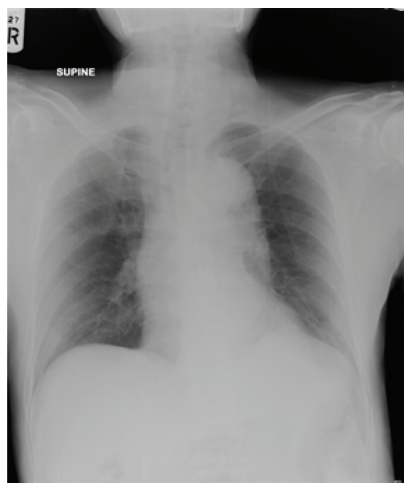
A Chest X-ray showing widening of mediastinum.
